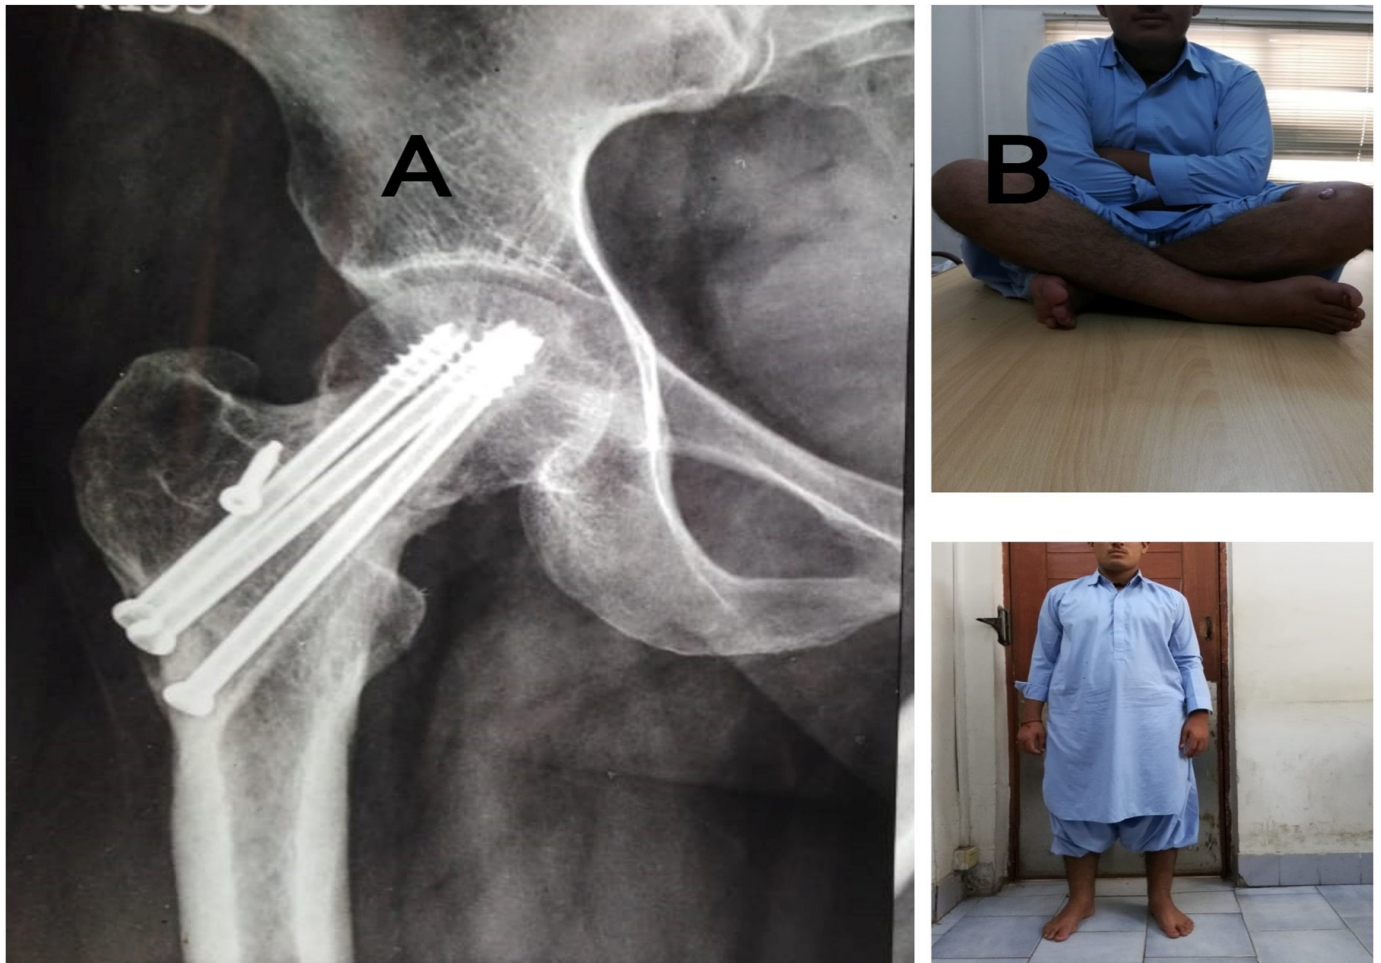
A showing postoperative Xray with Cannulated screw in situ , B denotes patient follow-up in standing and cross leg positions.
